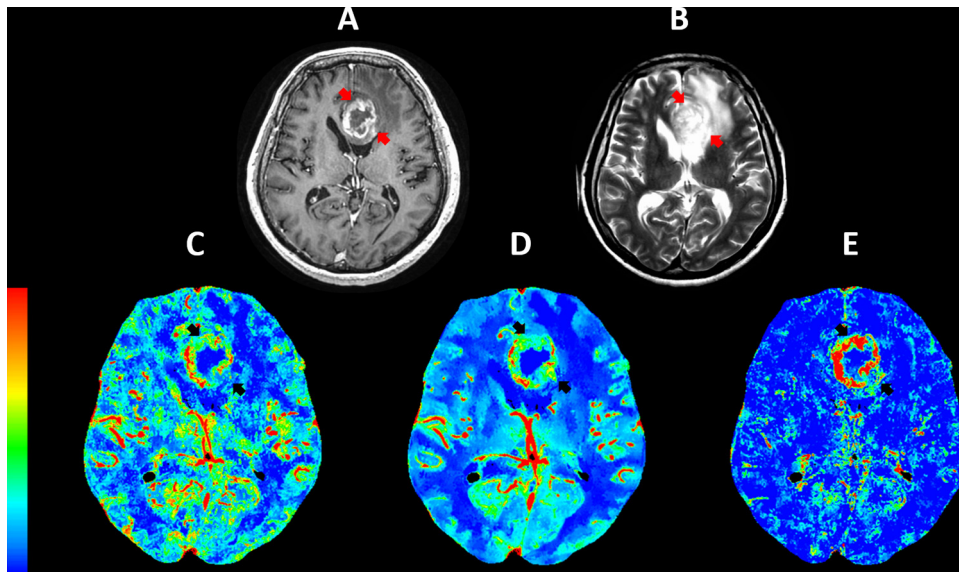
A patient with grade IV glioblastoma. Post-gadolinium T1-weighted image (A) shows a contrast-enhancing tumor (red and black arrows) and substantial peritumoral edema on T2-weighted image (B). Maps of blood flow (BF), blood volume (BV), and permeability-surface area product (PS) shows a rim with high BF, BV, and PS.
